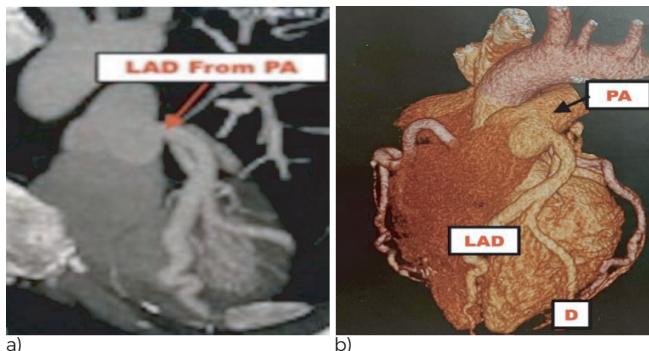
(a,b): 3-D reconstruction of a coronary CT angiogram showing the LAD arising directly from the main pulmonary artery rather than the left coronary sinus.
